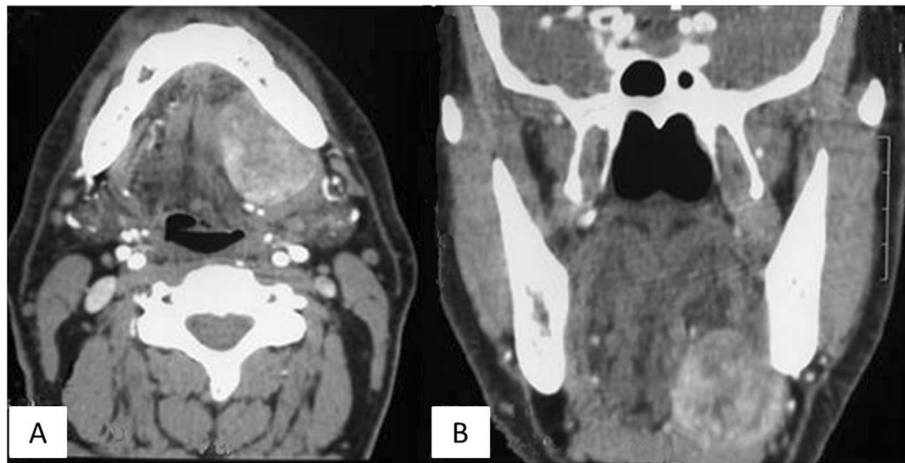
Post-contrast-computed tomography image. A Axial view. B Coronal view, showing an enhancing submandibular mass lesion in the left side
